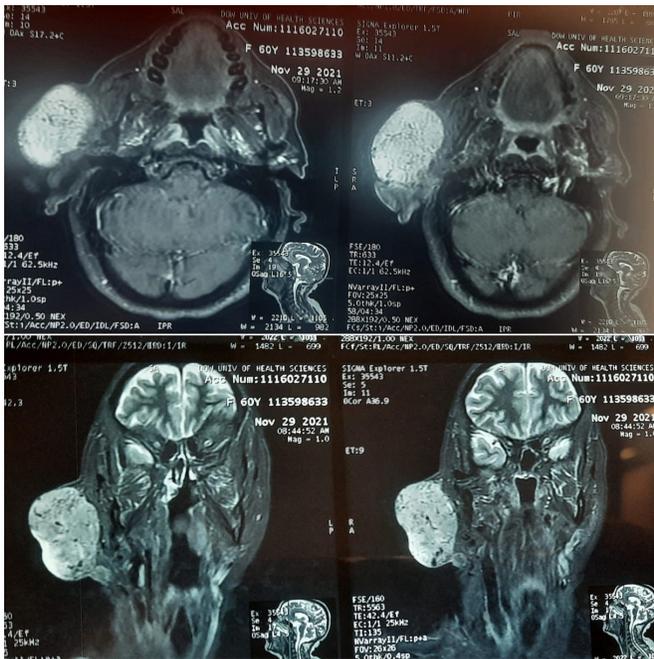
MRI scan of a patient showing a hyperintense lesion involving the right superficial lobe of the parotid gland.
